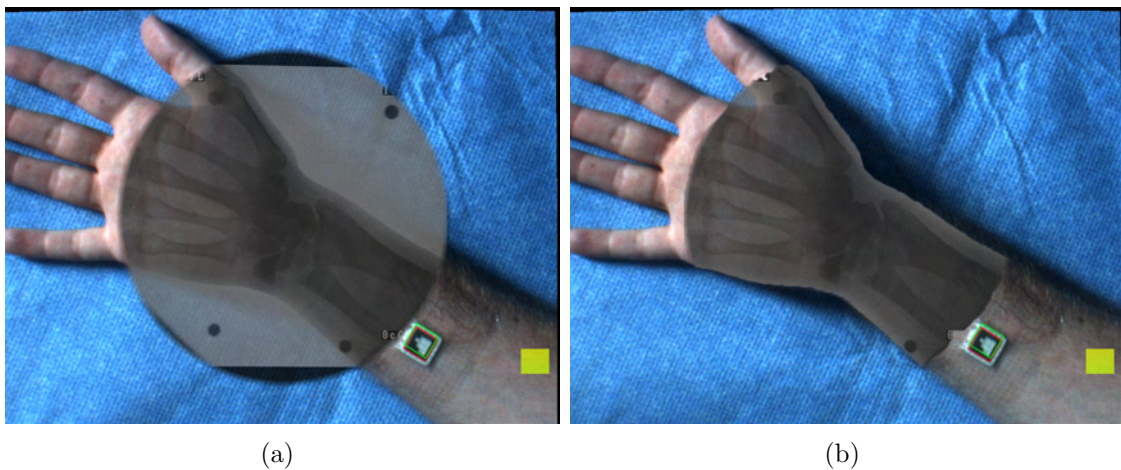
A mimic sample of removing the X-ray background that has no anatomical information from the overlay of a human hand: (a) The overlay of original X-ray and video image; (b) The overlay of the segmented X-ray and video image. The X-ray image is manually segmented.
